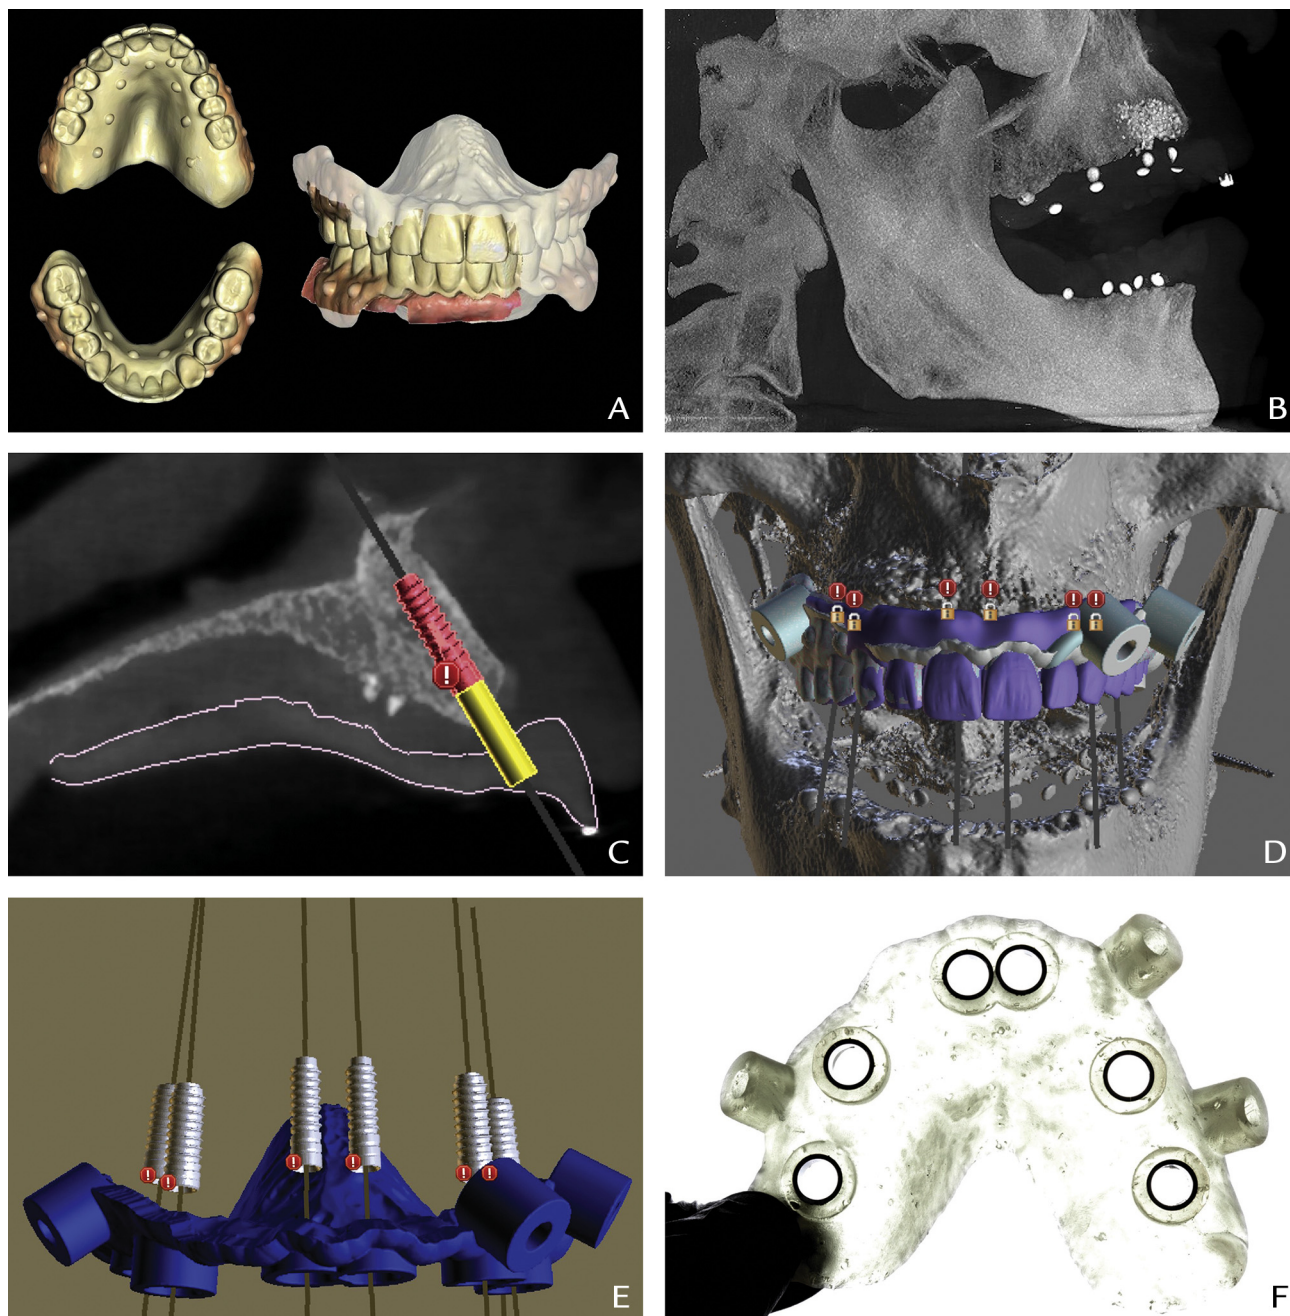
A, Digital scan of maxillary and mandibular tooth arrangement. B, CBCT scan with maxillary and mandibular tooth arrangement. C, Virtual implant treatment plan and superimposition of STLTA and CBCT1. D, E, Surgical guide design. F, Surgical guide. CBCT, cone beam computed tomography; STL, standard tessellation language.
